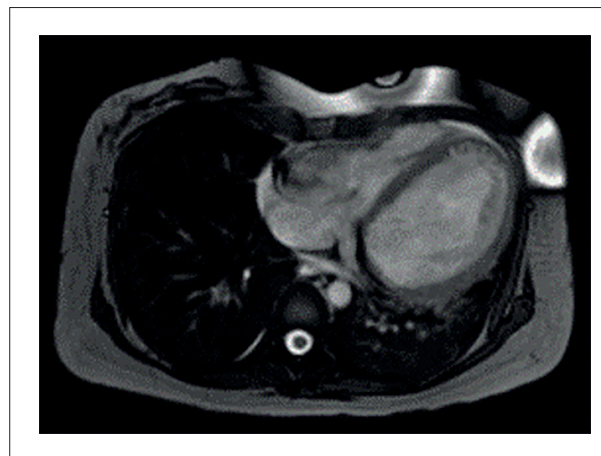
Cardiac magnetic resonance imaging showing important ventricular dilation of 166 × 132 ml/m², important right ventricular dysfunction, and important increase in left ventricular trabeculation, not meeting the criteria for noncompaction.
